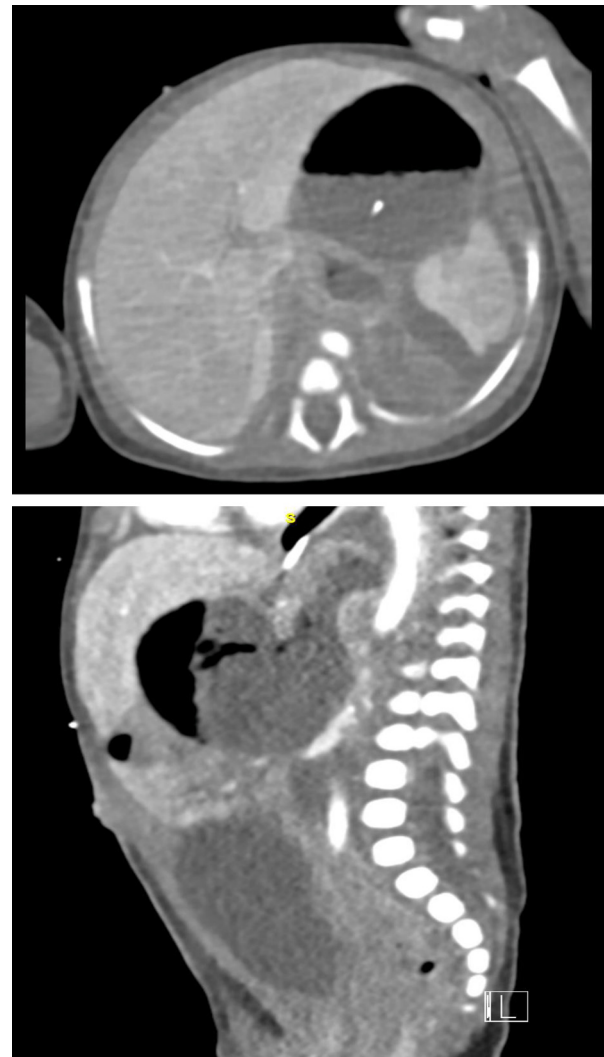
Day of life 7. Axial CT demonstrates the feeding tube passing through a normally positioned gastroesophageal junction into the gastric lumen, anterior to a herniated pylorus. Sagittal CT demonstrates herniation of the gastric antrum above the diaphragm, posterior to the gastroesophageal junction.
